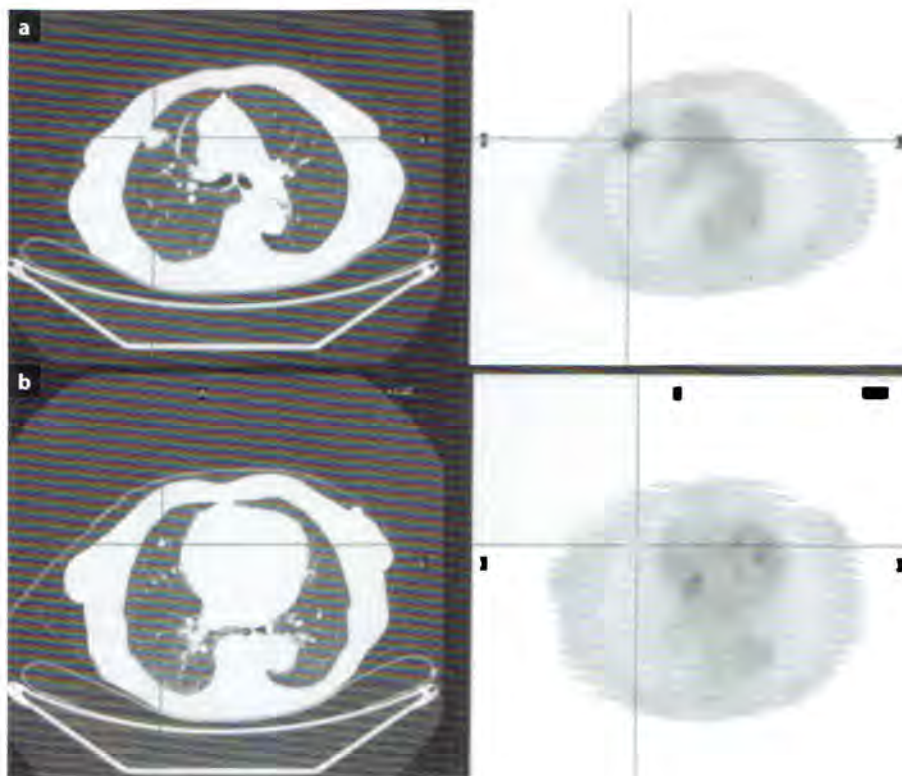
Combined CT/PET study showing axial CT images with the corresponding FDG-PET images registered to the same slice position. a A malignant lung lesion with high ^{18}F FDG uptake on the PET image. b An incidental benign granuloma which does not show high uptake
